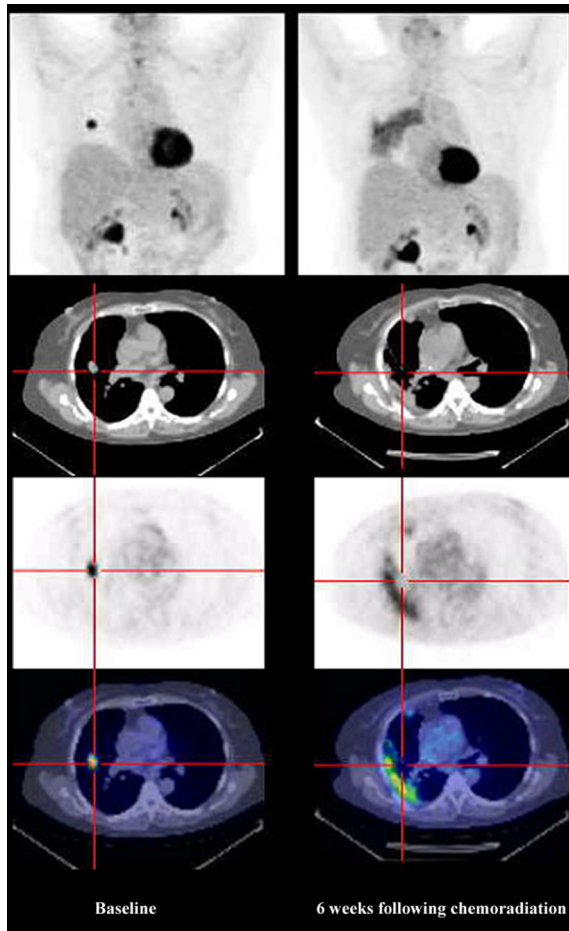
Maximum intensity projection (MIP) images (above) of the baseline (left) and follow-up (right) FDG PET studies demonstrate a change in the distribution of metabolic abnormality from focal uptake related to a known non-small cell lung cancer to a geographic pattern consistent with radiation pneumonitis within a radiation portal. The reference transaxial CT images at the level of the primary tumour in the right mid-zone (upper) demonstrate almost complete resolution of the primary lesion but progressive pleurally based changes. Corresponding transaxial PET (middle right) and PET/CT fused (lower right) images following treatment demonstrate no uptake in the primary tumour site but increased activity related to the radiographic abnormality. Based on the pattern of abnormality, no further treatment was given. Although progressive radiation fibrosis of the lung was observed, no local recurrence has been confirmed. The SUV in the presumed area of pneumonitis was similar to that recorded for the primary tumour at baseline demonstrating the limitations of relying purely on semi-quantitative measures to differentiate between benign and malignant processes.
